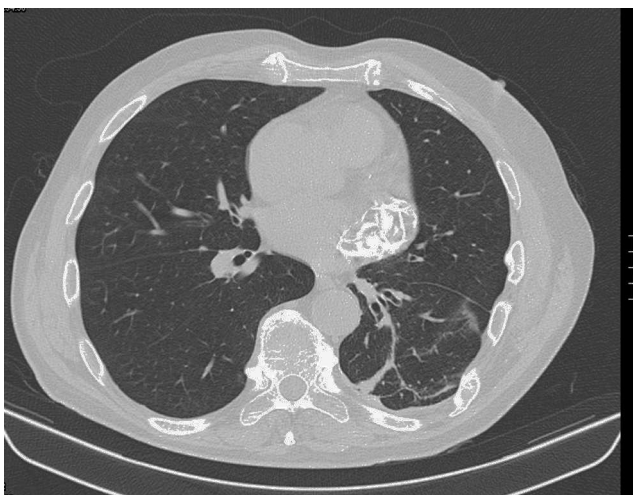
Thoracic computed tomography angiogram showing lesion after contrast injection.
